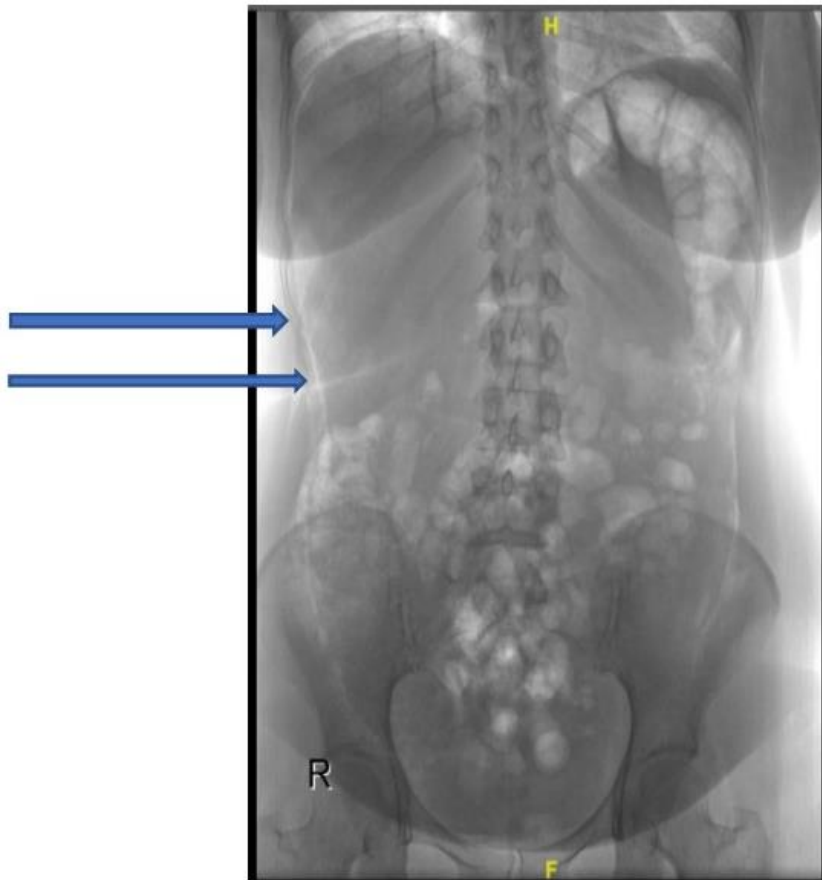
abdominal xray- upright showing pneumoperitoneum as depicted by the blue arrows.
